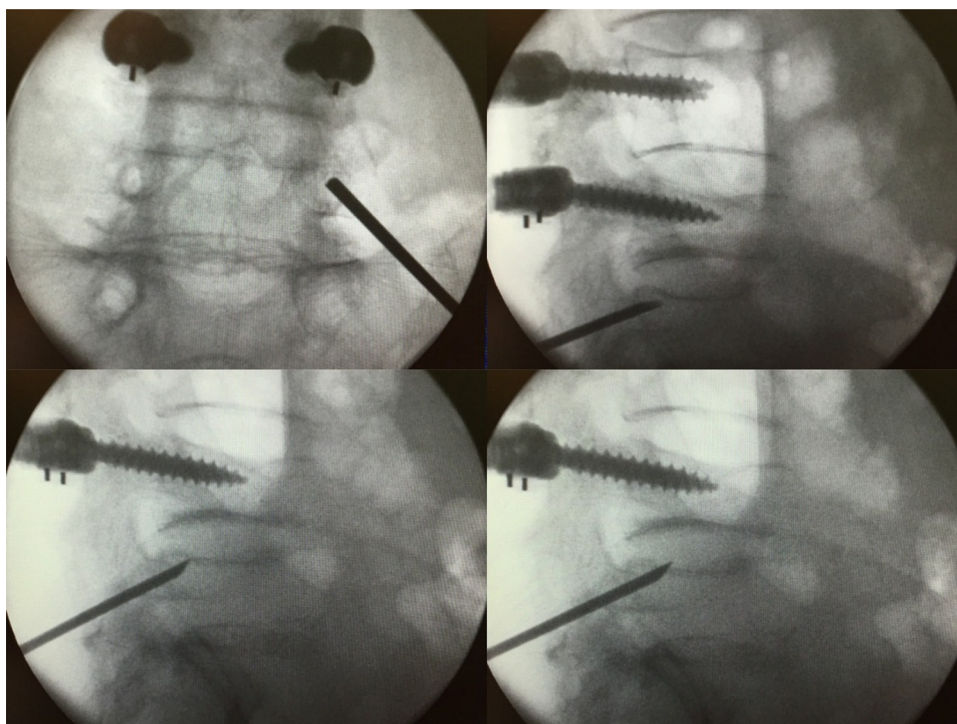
Sequence of AP and lateral x-ray views during introduction of the needle through pedicle.
